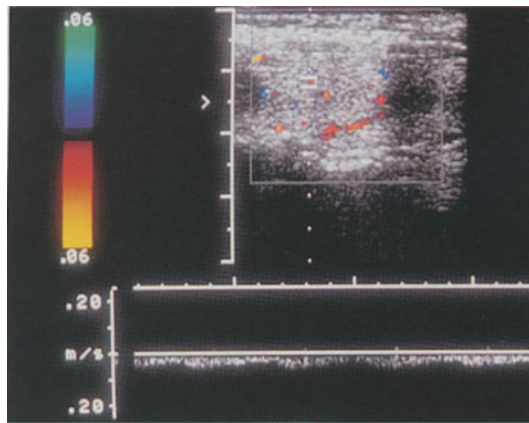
(left) Most of the vessels normally shown within the thyroid gland are veins, as indicated here by pulsed Doppler evaluation with spectral waveform display
